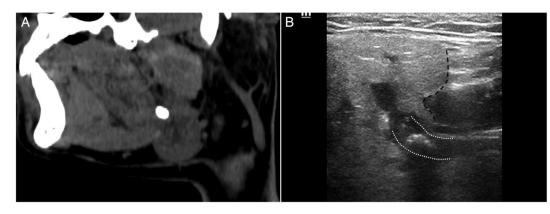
(A) A hilar stone located just at the hilum of Wharton's duct. (B) The ultrasonography showed the stone at the hilum region (white dotted line) of the main duct. Note the antierior boundary of the gland (black dotted line) (type I).
